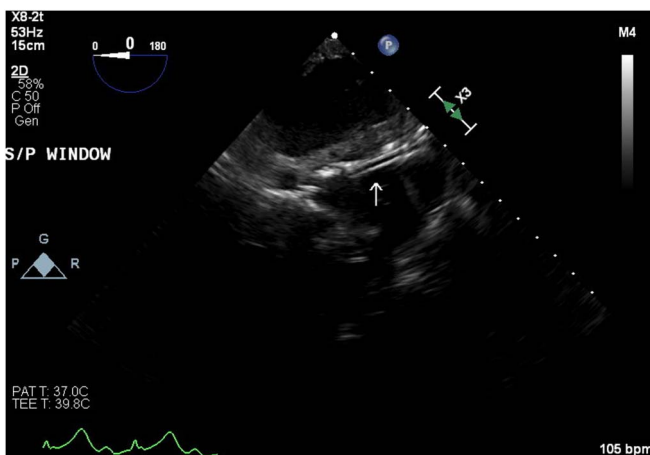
Transthoracic echocardiogram with the biliary stent (arrow) in the pericardial space.
